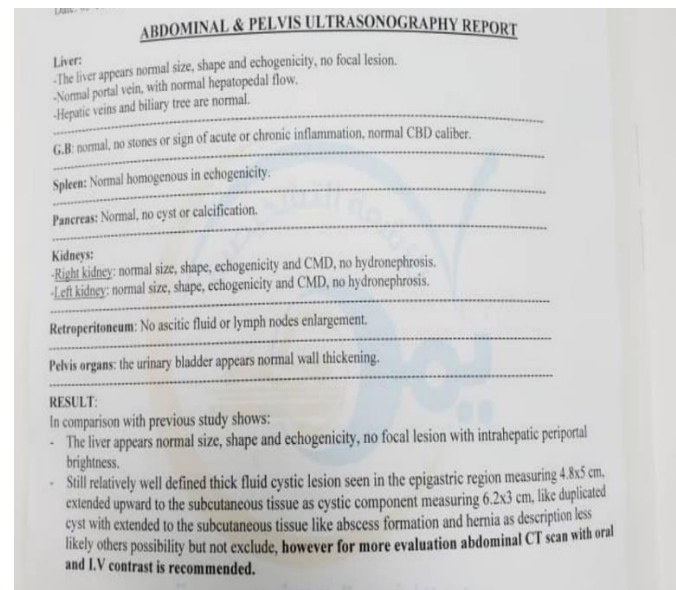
Abdominal and pelvis ultrasonography report.
